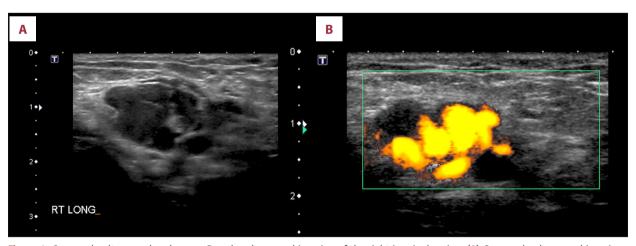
Gray-scale ultrasound and power Doppler ultrasound imaging of the right inguinal region. (A) Gray-scale ultrasound imaging of the right inguinal region shows a predominantly hypoechoic lesion composed of multiple, hyper vascular, echo-free tubular channels. The imaging findings are consistent with round ligament varicosities. (B) Power Doppler imaging of the right inguinal region shows a predominantly hypoechoic lesion composed of multiple, hyper vascular, echo-free tubular channels. There is no sonographic evidence of an inguinal hernia. The imaging findings are consistent with round ligament varicosities.
